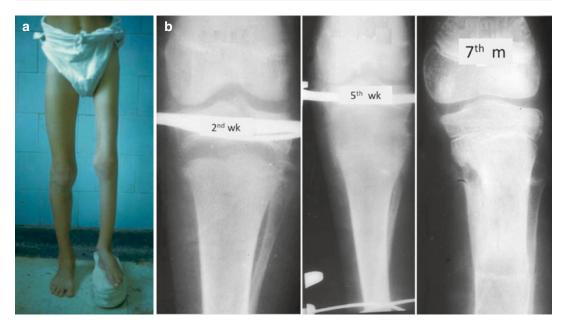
The first patient who underwent a lengthening procedure in our clinic. Clinical photo and follow up X-rays
